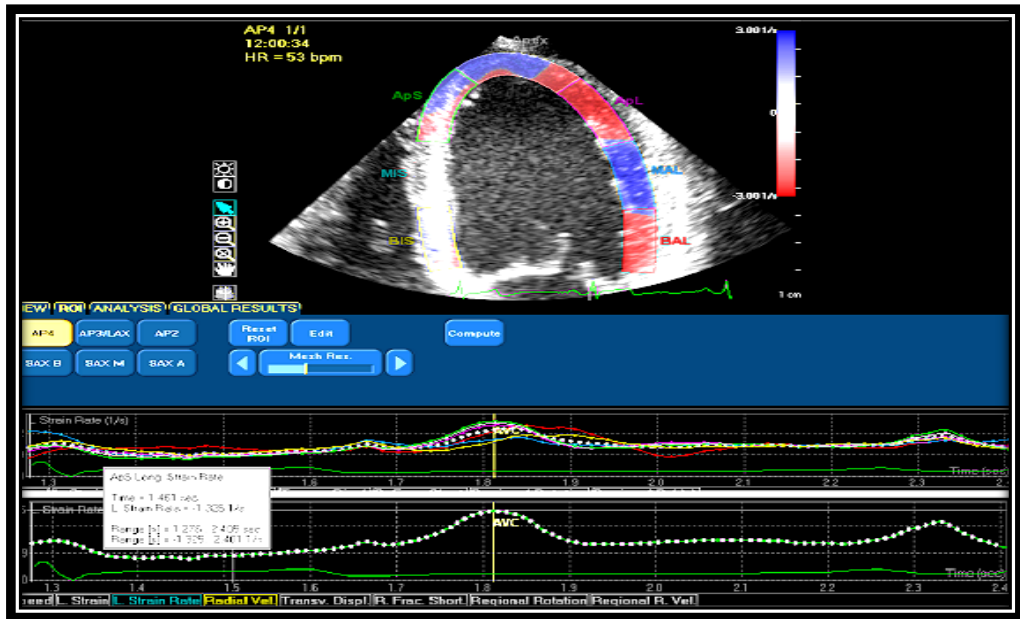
Measurement of the systolic longitudinal strain rate in STE. The upper part of the figure shows measurements of several segments in the apical four-chamber view with a cluster of strain rate lines in the panel underneath. The bottom of the figure shows an individual line from the apical septal segment after other segments were removed. From this line, the deepest systolic strain rate is $-1.325/s$.
